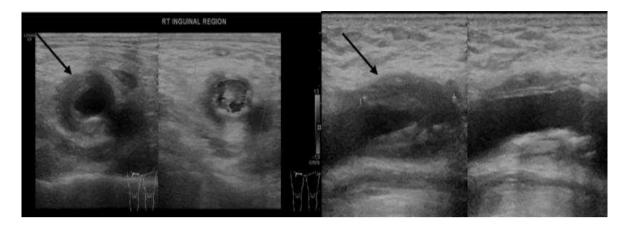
Initial ultrasound finding of the right inguinal swelling on transverse (3a) view and longitudinal (3b) view shows focal area of wall thickenings (black arrows) associated with surrounding soft tissue echogenicity involving the right external iliac artery, which is confirmed on CT angiogram
